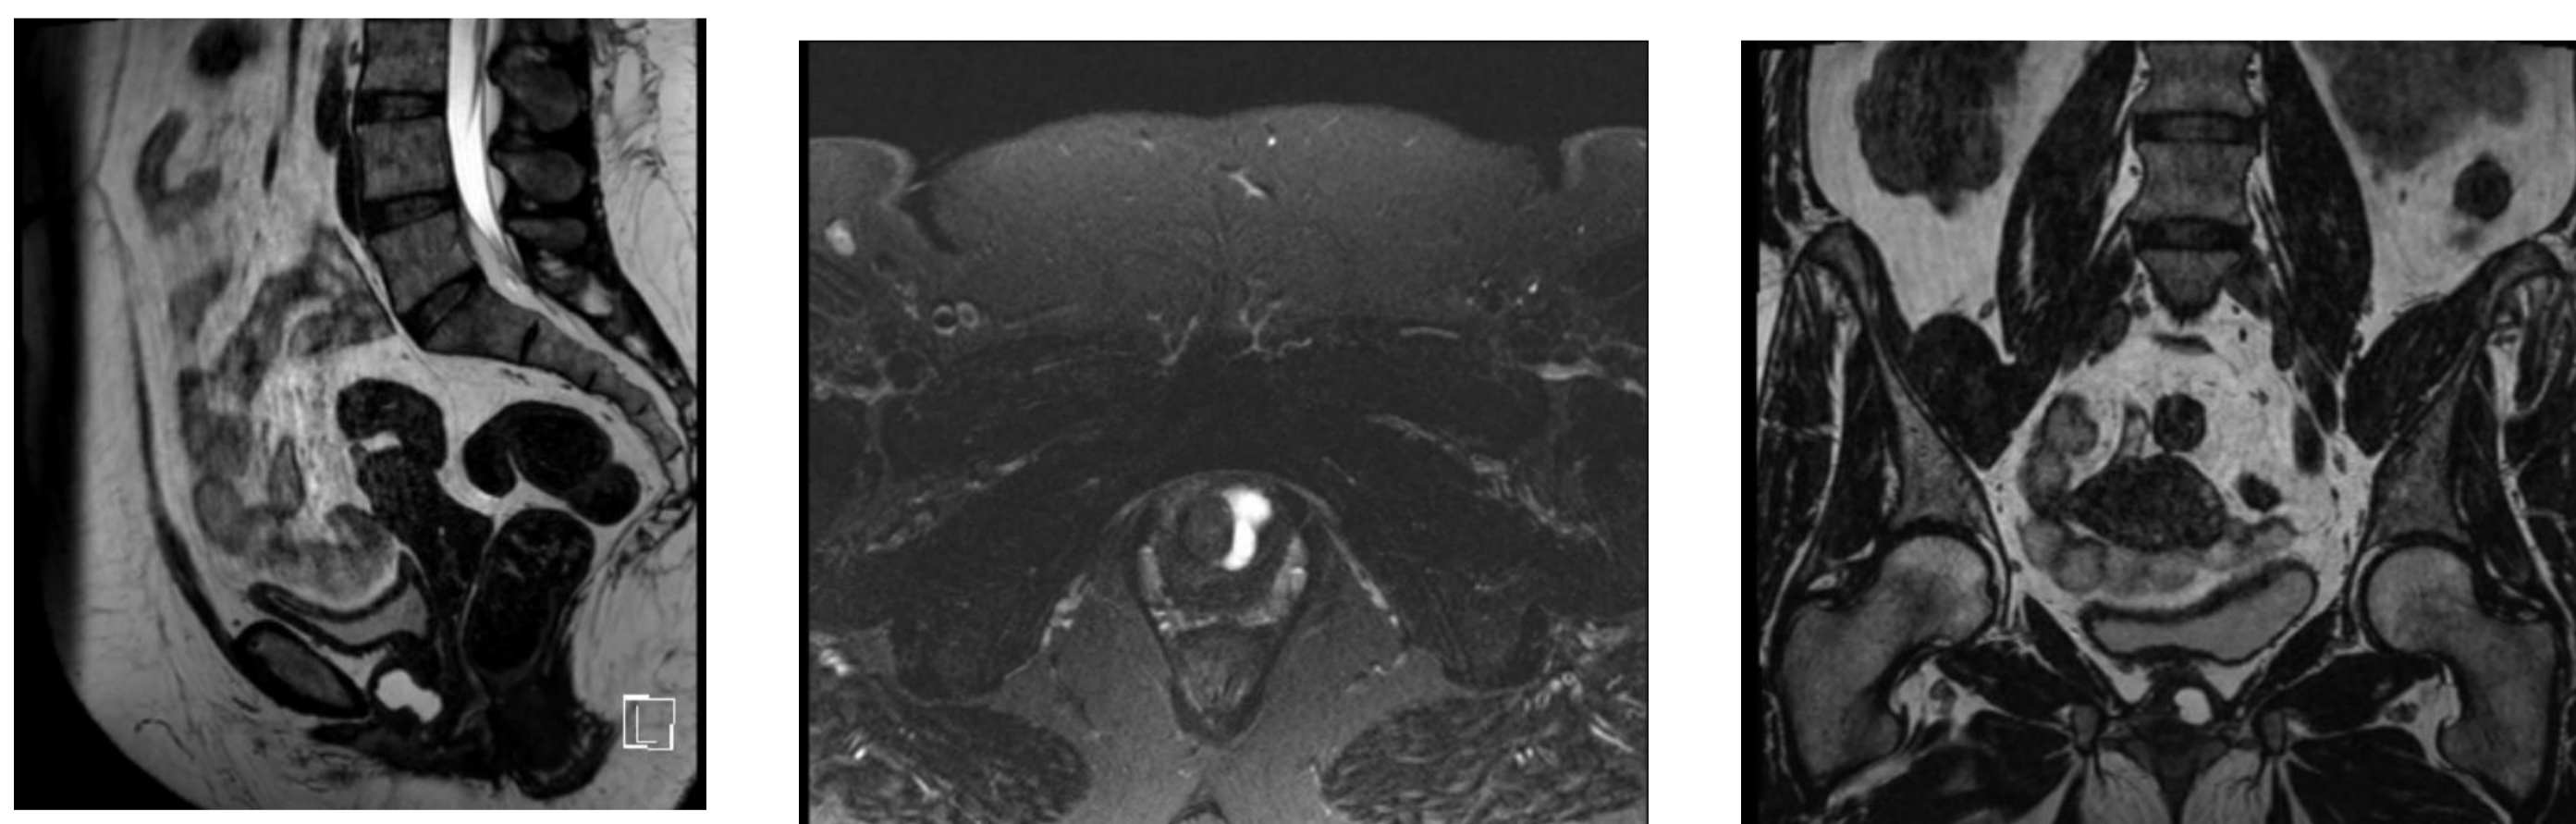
A urethral diverticulum on MRI
